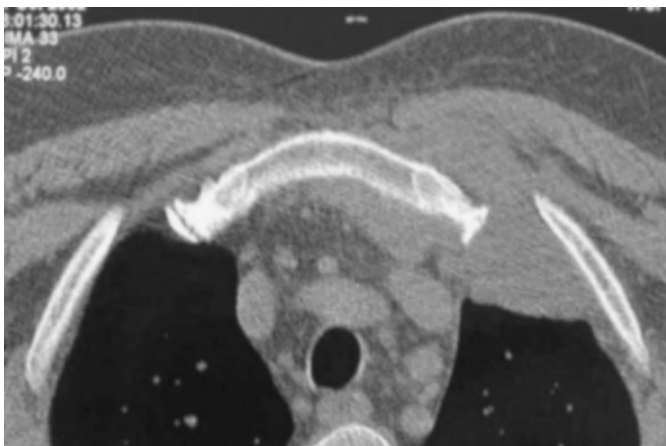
(CT scan bone window): Dilation of the first sternocostal junction due the presence of a soft mass with intrathoracic extension, and a slight destruction of the left sternal edge is observed.
